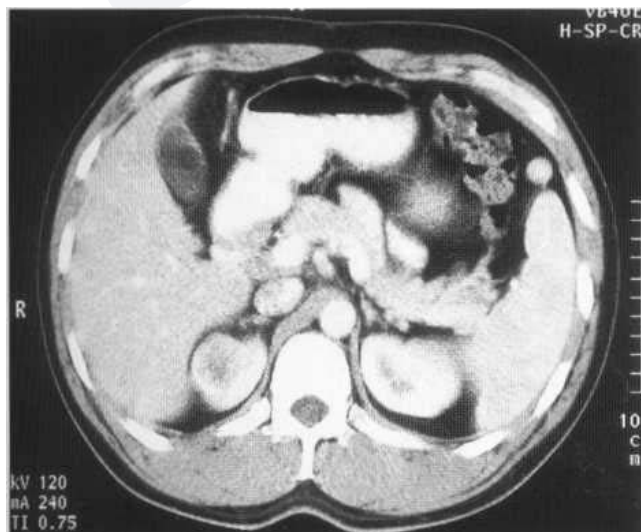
Stage I renal cell carcinoma on postcontrast CT. The tumour is small and confined to the kidney.
